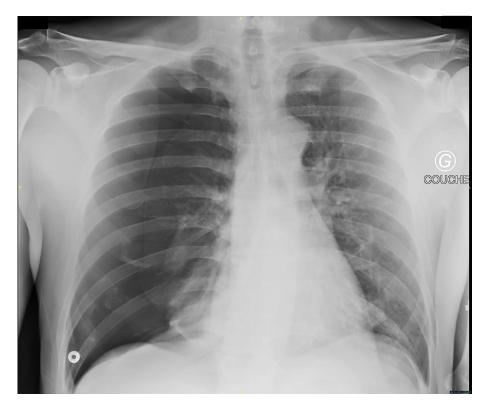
Radiograph of chest showing a complete right pneumothorax
